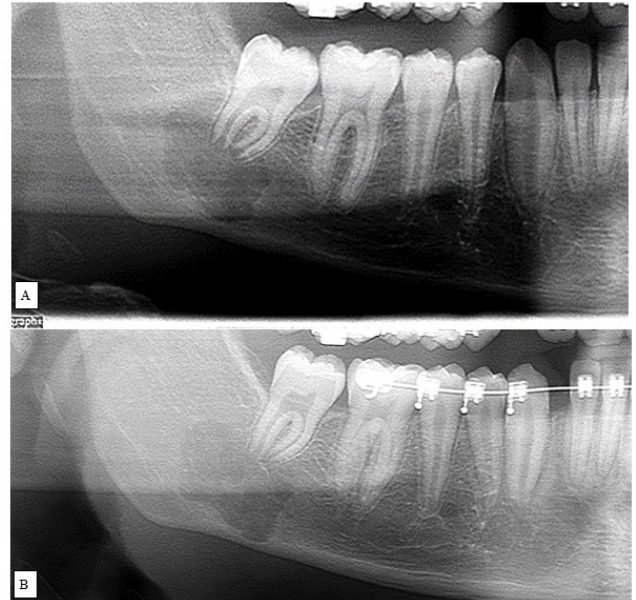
Follow-up panoramic radiographs taken at 6 months intervals before (A) and after (B) the placement of fixed appliances on the mandibular teeth
